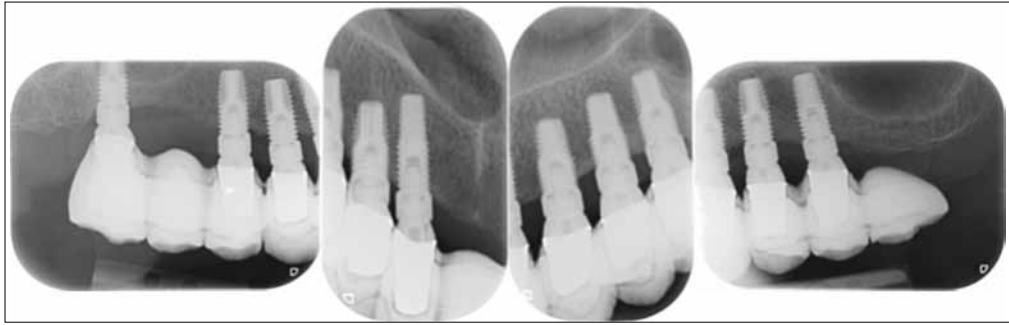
Three years follow-up; intraoral radiograph.
